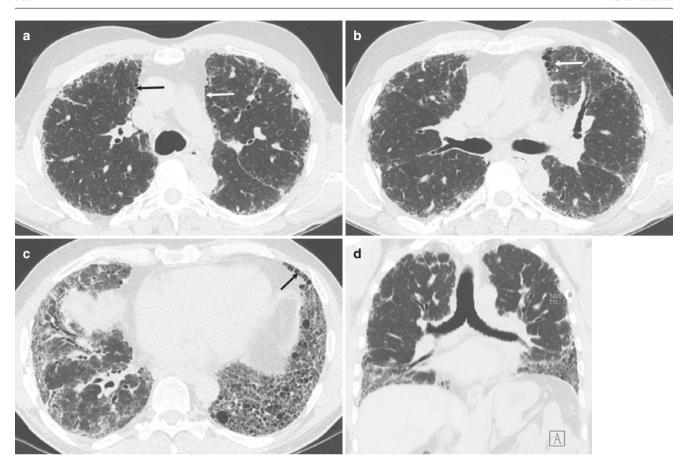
Typical UIP. (a-c) Axial CT images show peripheral predominant reticular opacities, honeycombing (arrows) with traction bronchiectasis and GGOs. (d) Coronal CT image is useful to confirm
